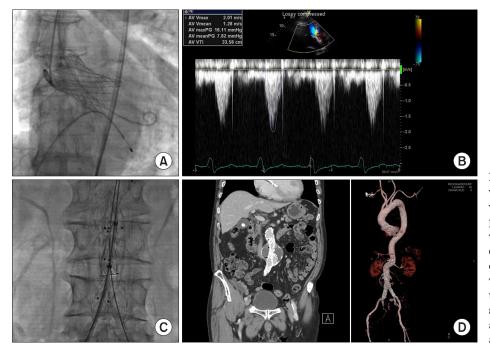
(A, B) In transcatheter aortic valve replacement, a self-expandable valve prosthesis was deployed, with improvement of valve parameters (peak velocity of 2.04 m/s, mean pressure gradient of 7.9 mmHg, and aortic valve area of 1.42 cm^2). (C) A main body stent graft was implanted during endovascular aortic repair. (D) Computed tomography showed good patency of valve prosthesis at the aortic valve, and endoprosthesis at the lower part of abdominal aorta.
